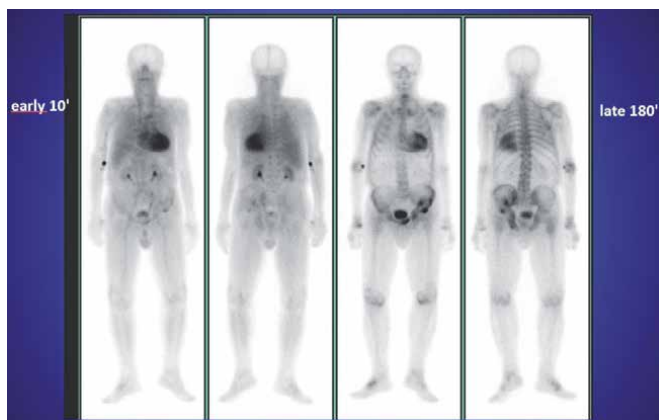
Cardiac uptake grading in bisphosphonate scintigraphy shows similar myocardial and bone uptake. Courtesy of Dr. R. Giubbini.
